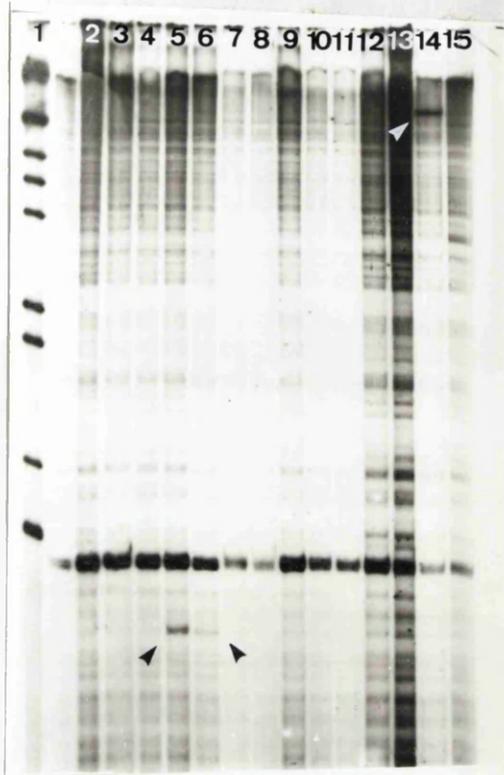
Detection of mutations by AMD analysis of patients with porphobilinogen deaminase (PBG-D) deficiency. Lane 1: Size marker (1 kb ladder). Lane 2: patient with G(606)→T mutation. Lane 3: patient with G(135)→A. Lane 4: patient with  $\Delta$ CT(730-731) mutation . Lane 5: patient with C(100)→A and G(606)→A mutations shows a cleavage at position of 100 bp. Lane 6: patient with C(100)→A mutation shows a cleavage at position of 100 bp. Lane 7: patient with C(610)→T mutation. Lane 8: patient with unknown mutation. Lane 9: patient with unknown mutation. Lane 10: patient with G(606)→T mutation. Lane 11: patient with G(848)→A mutation. Lane 12: patient with T(761)→C. Lane 13: patient with G(1002)→A mutation shows a cleavage at position of 754 bp. Lane 14: patient with G(754)→A. Lane 15: patient with G(789)→A mutation.
